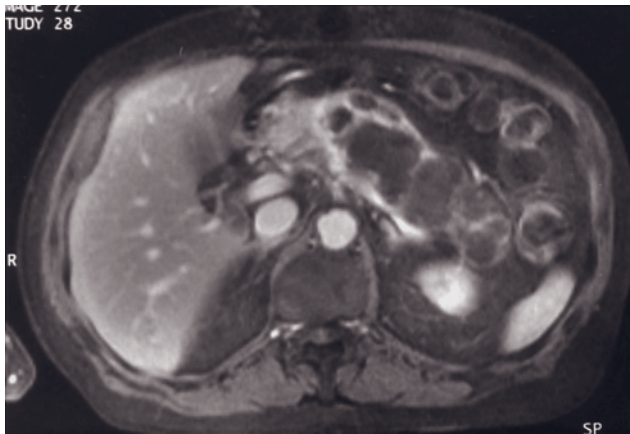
Mucinous (macrocystic) cystadenoma. T2-weighted SS-ETSE (a) and 90-s postgadolinium fat-suppressed T1-weighted SGE (b) images. A well-defined cystic mass arises from the body and tail of the pancreas that is low in signal intensity on the T1-weighted image (not shown) and high in signal intensity on the T2-weighted image (a) and demonstrates enhancement of septations on the postgadolinium T1-weighted SGE image (b). No evidence of tumor nodules, invasion of adjacent tissue, or liver metastases is appreciated. The uniform thickness of the septations is clearly defined on the breathing-independent SS-ETSE image (arrows, a). Mucinous cystadenoma is potentially a low-grade malignant neoplasm.
